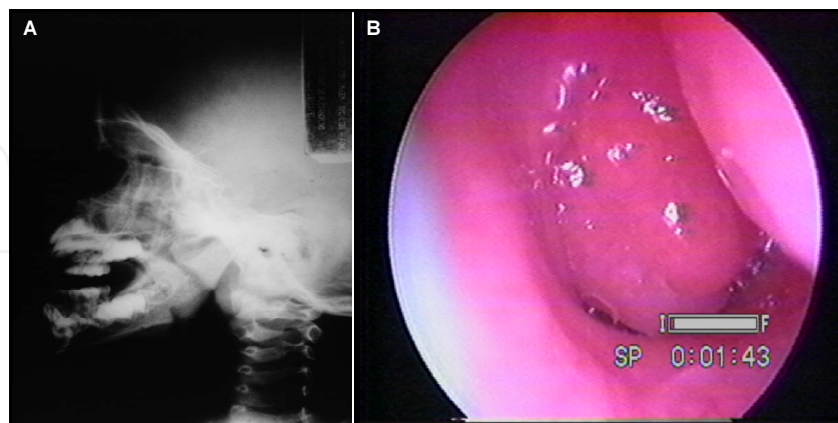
Adenoid hypertrophy. (A) Lateral X-Ray; (B) Endoscopic view, with important obstruction in nasopharynx due to adenoid hypertrophy.
